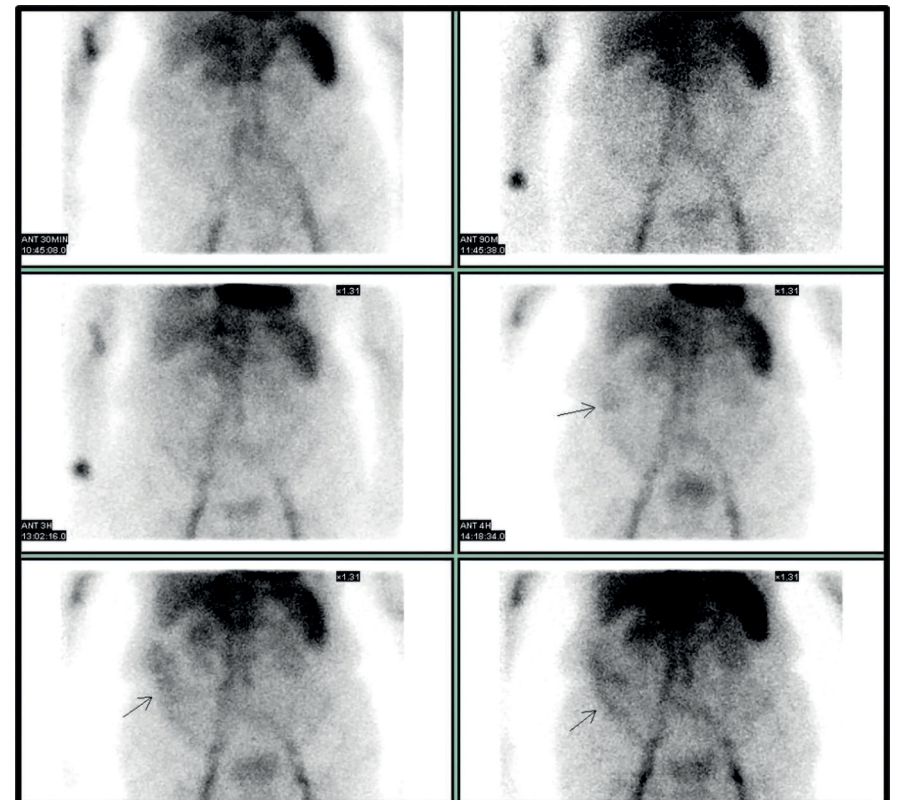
74-year-old woman with melaena. Colonoscopy was inconclusive. Gastrointestinal bleeding scintigraphy was performed: abnormal RBC accumulation was observed in the periphery of right flank (arrow) and related to active bleeding in ascending colon. The scan was positive only 4 hours after ^{99m}Tc -RBC injection. RBC – red blood cells.
